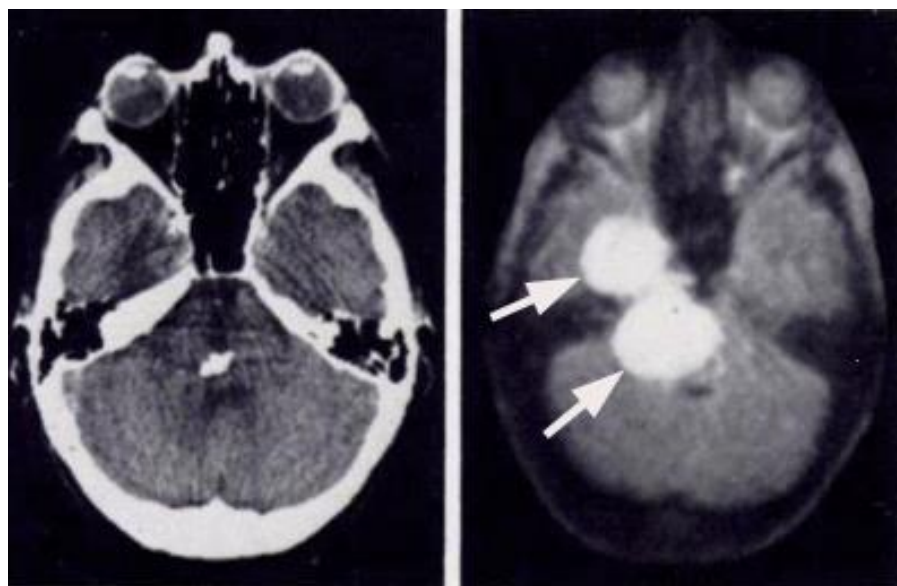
Chondroma in the posterior and middle cranial fossae: CT (left) and heavily T₂ weighted SE scan (right). Calcification is seen as high signal (light) in the region of the pons on the CT scan but the tumour is much better seen on the SE scan (arrows). The calcification appears dark on the MR scan.
